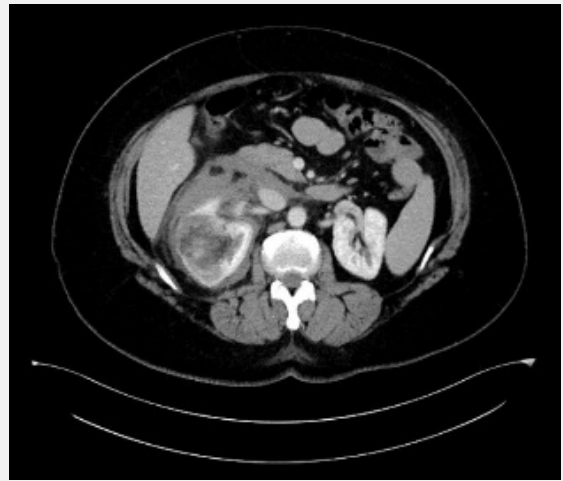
Computed tomography abdomen scan with contrast.
